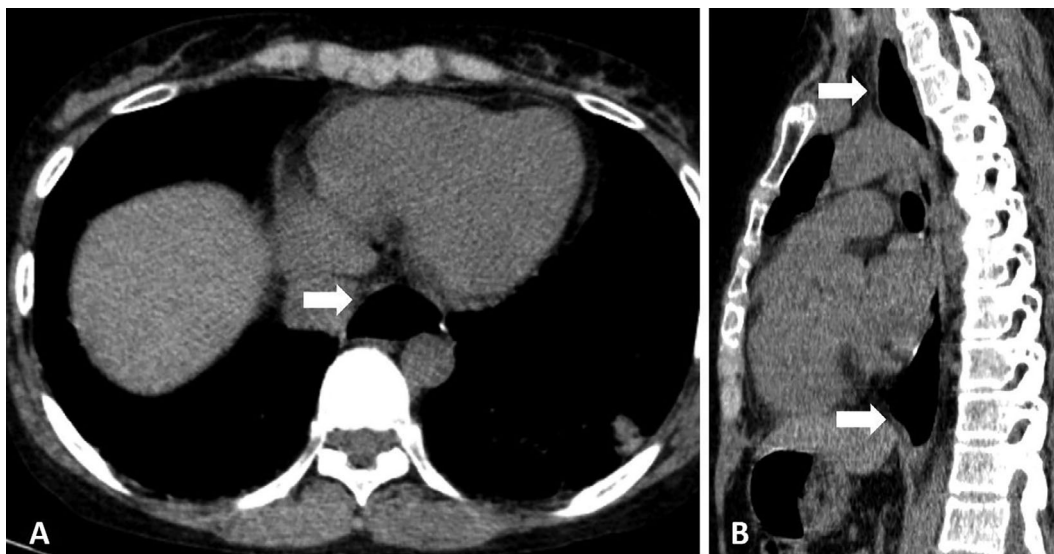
Axial and sagittal reconstruction computed tomography images demonstrated multiple segmental oesophageal dilatations without evidence of obstruction, compatible with oesophageal dysmotility
